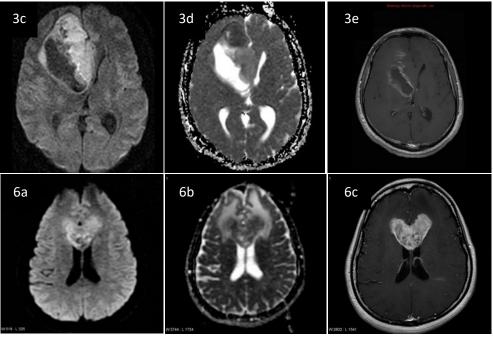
3: 3c: axial DWI; 3d: axial ADC; 3e: axial T1 CEWI. 6: GBM NOS with subarachnoid spread, with giant cell GBM component, adult. 6a: axial DWI; 6b: axial ADC; 6c: axial T1 CE. Adapted from: 3: Case of Dr Ahmed Abdrabou, Radiopaedia.org, rID: 22779 and from: 6: Case of A.Prof Frank Gaillard, Radiopaedia.org, rID: 5290
